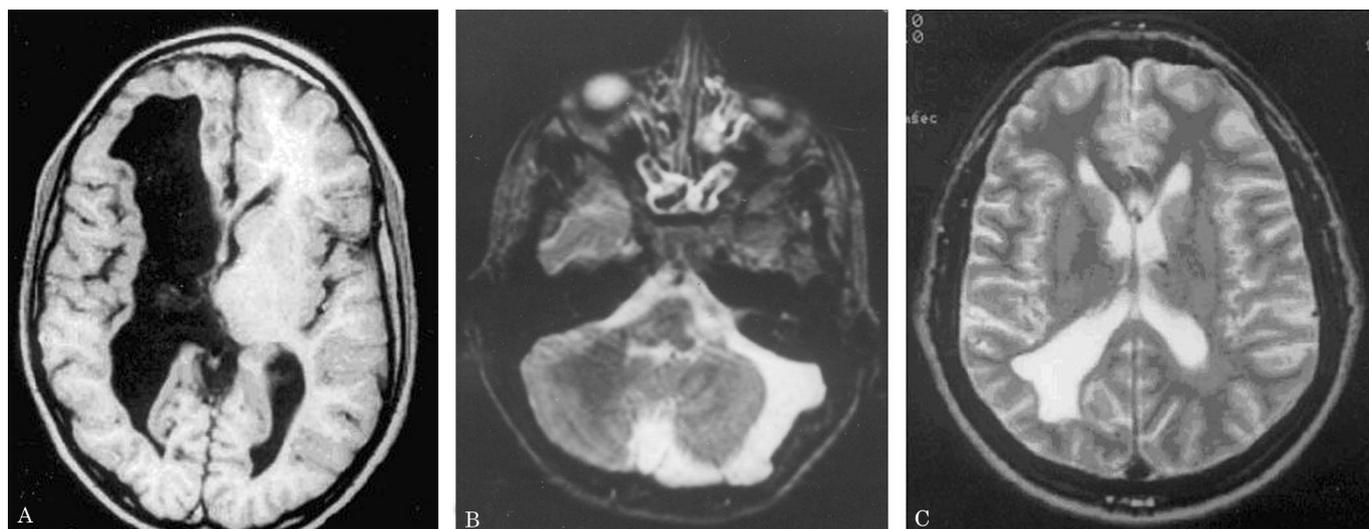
(A and B) MRI of severe autosomal dominant type 1 porencephaly: Patient IV16. There is a large porencephalic cyst involving both subcortical gray and white matter of the whole right hemisphere (A). Crossed cerebellar atrophy is evident (B). (C) MRI of mild autosomal dominant type 1 porencephaly: Patient III9. There is slight enlargement of a ventricle's occipital horn. No other brain abnormalities and no MRI evidence of abnormal cortical gyral pattern are seen.
